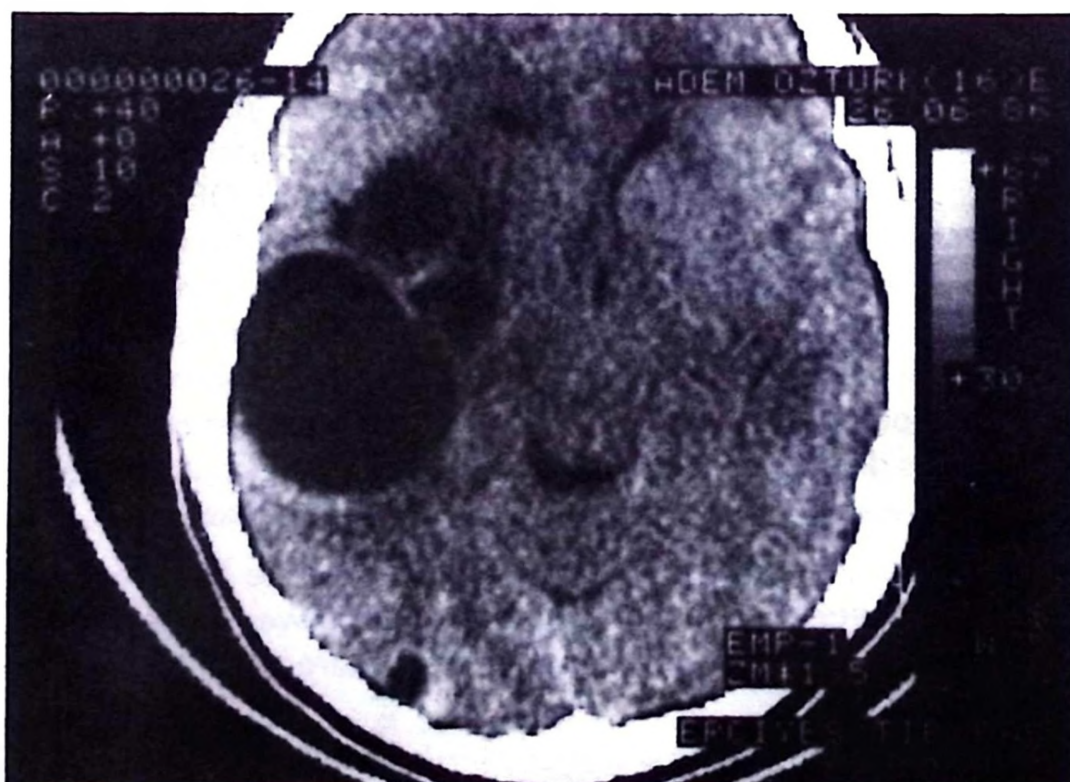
CT scan showing multiple hydatid cysts occupying the left supratentorial region. Note the peripheral rim enhancement following intravenous contrast injection, and the small occipital hydatid cyst.
